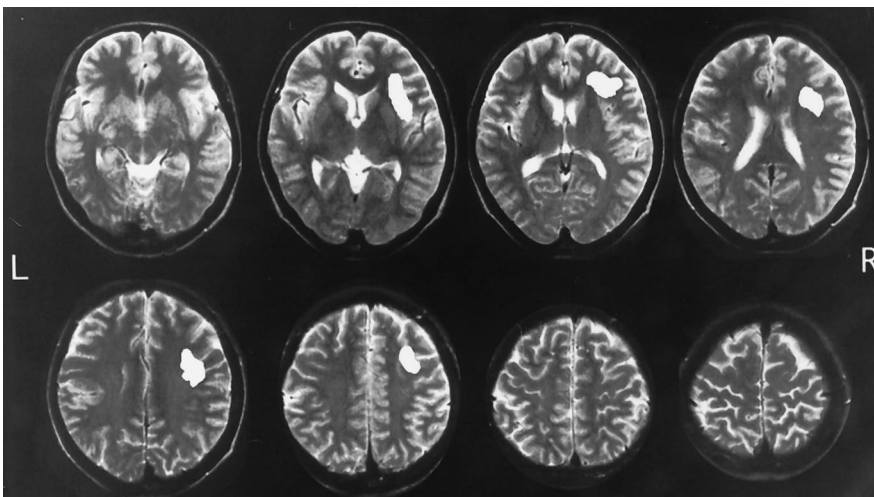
Common MRI lesions of 10 patients with simultanapraxia shown by the overlaying method. The lesions are located in right frontal areas 6 and 8.
